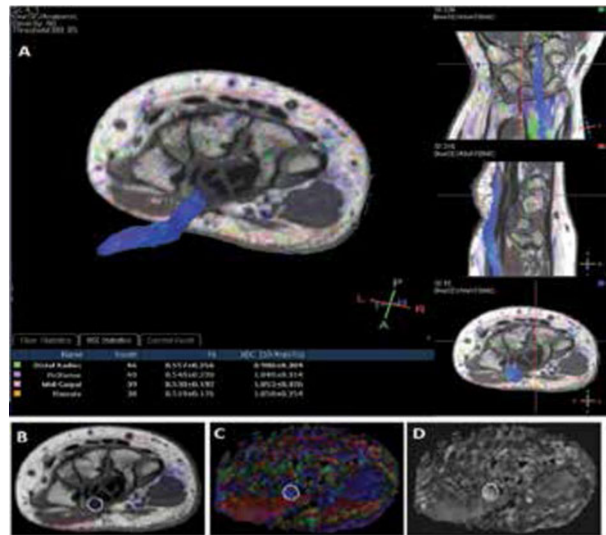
Topography of the median nerve, coded in blue, with superimposed on the coronal reference 3D-T2 weighted image (A) diffusion tensor imaging with superimposed on the posterior reference axial T2-weighted image (B) color coded FA map image (C) FA map image (D). Regions of interests were placed manually, surrounding the median nerve. (SLC2)
